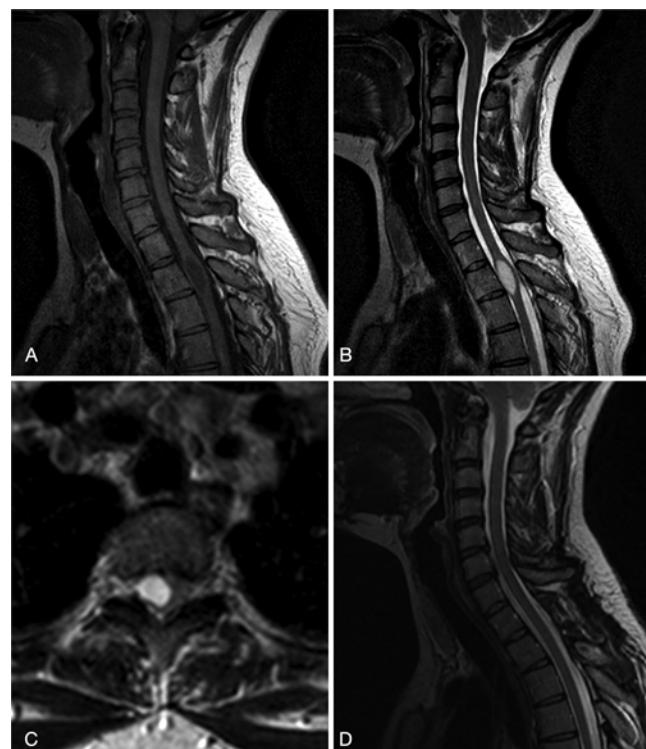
Example of a spinal subependymoma. A 35-year-old woman presented with right arm pain, numbness, tingling, and difficulty opening jars/bottles with her right hand. Preoperative MRI shows a 2.2-cm thoracic intramedullary mass at the level of the T2 vertebrae. The mass is well defined, T1 hypointense (A), T2 hyperintense (B), and eccentric to the right with cord displacement (C). There was no contrast enhancement in postcontrast imaging. The patient underwent a T1–T2 laminoplasty for GTR as seen on sagittal T2-weighted MRI 8 months after the surgery (D). Pathology was consistent with subependymoma.
